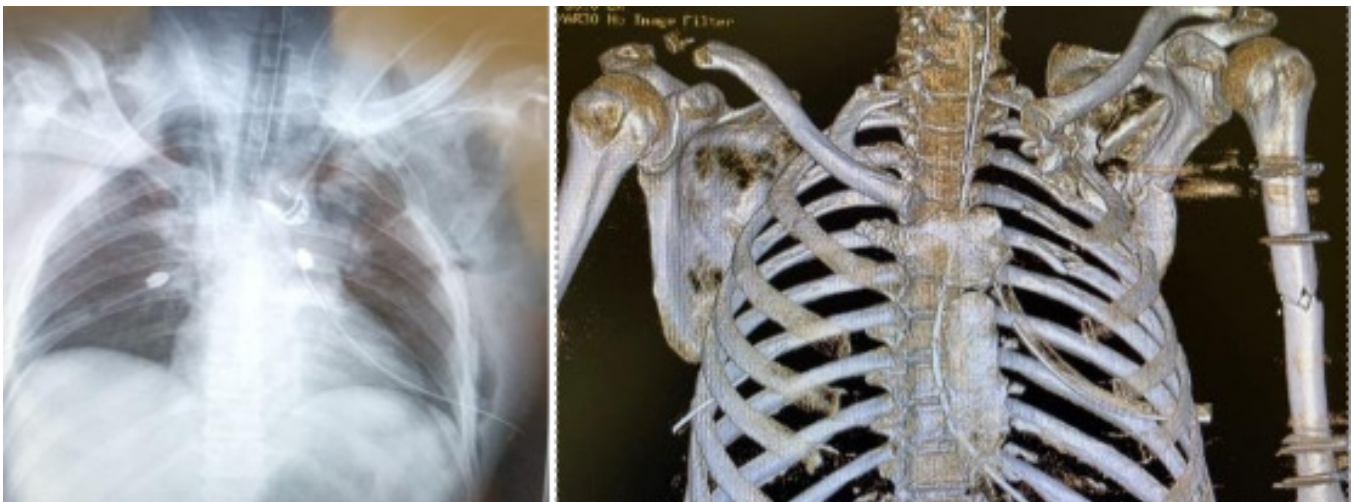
Preoperative radiographs and CT scan showing: bilateral sternal clavicular dislocation with inferior sternal migration, multiple left rib fractures, lateral right clavicular fracture, left scapular fracture and left humeral shaft fracture.
